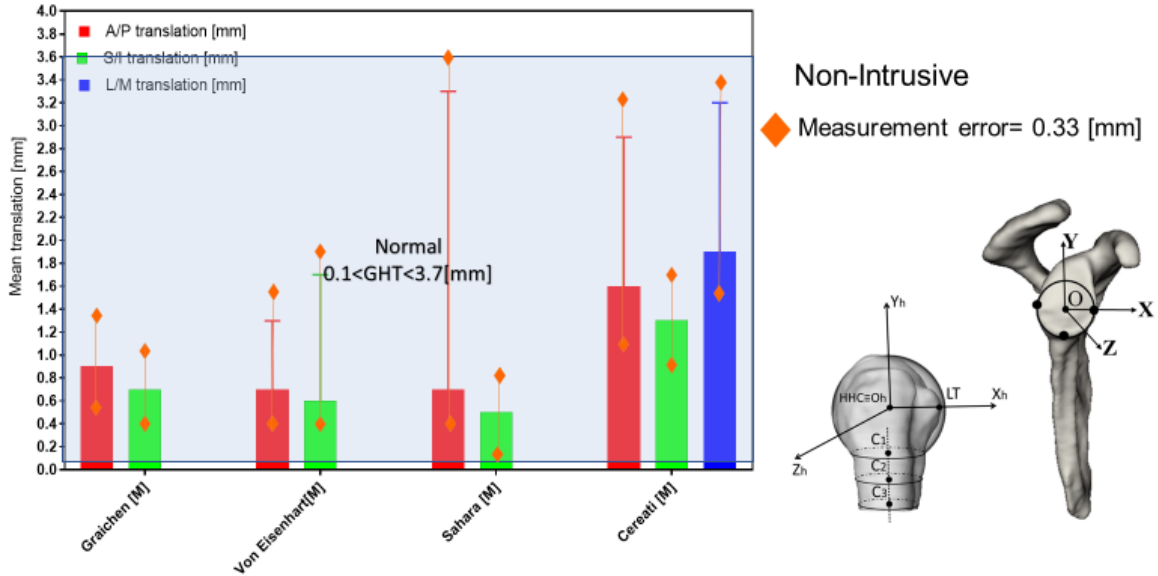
Peak Glenohumeral translations with MRI
